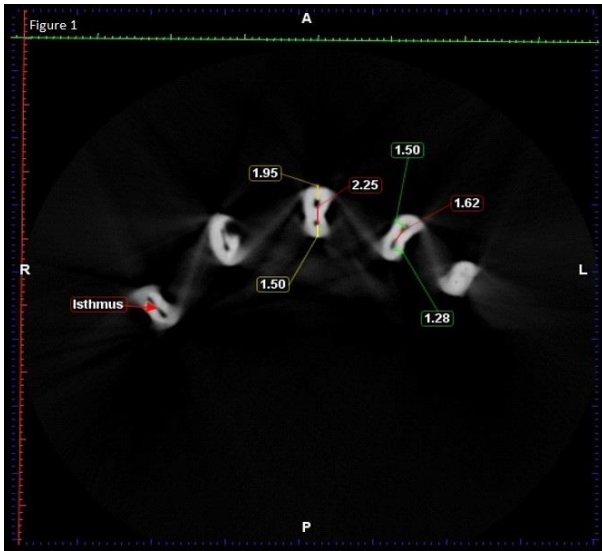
Isthmus, canal distance, and the distance between the outer root surface and root canals in the axial CBCT view
